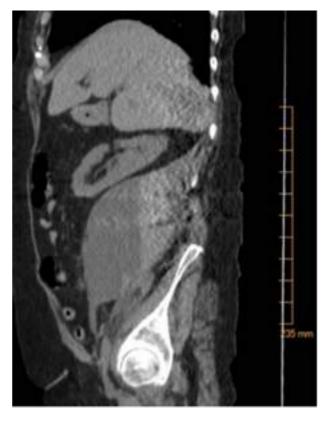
CT of abdomen and pelvis without contrast, showing large right-sided retroperitoneal mass (10×11×16 cm) concerning for hematoma of varying age.
